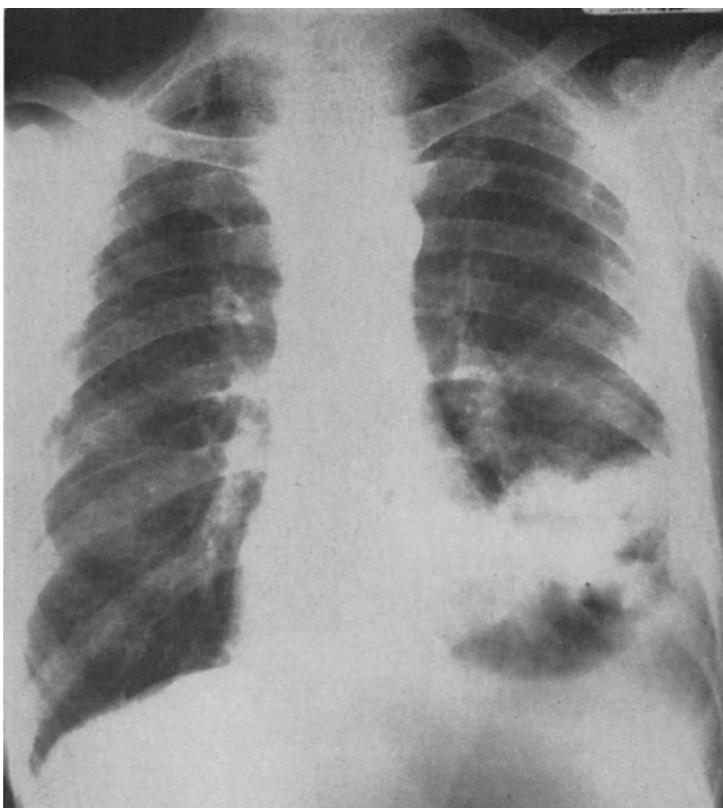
Posterior anterior radiograph showing a gas filled cavity
